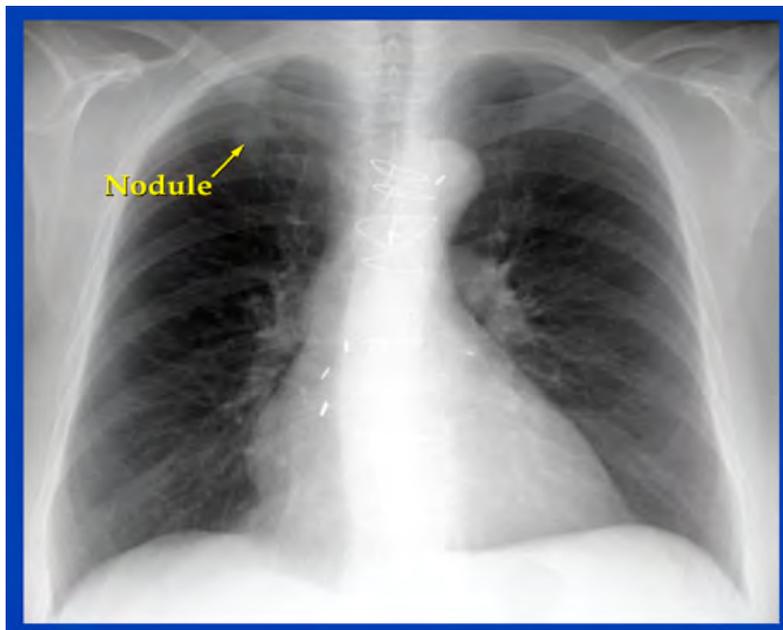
Chest x-ray showing a nodule (less than 3 cm in diameter) without spread to adjacent structures.
